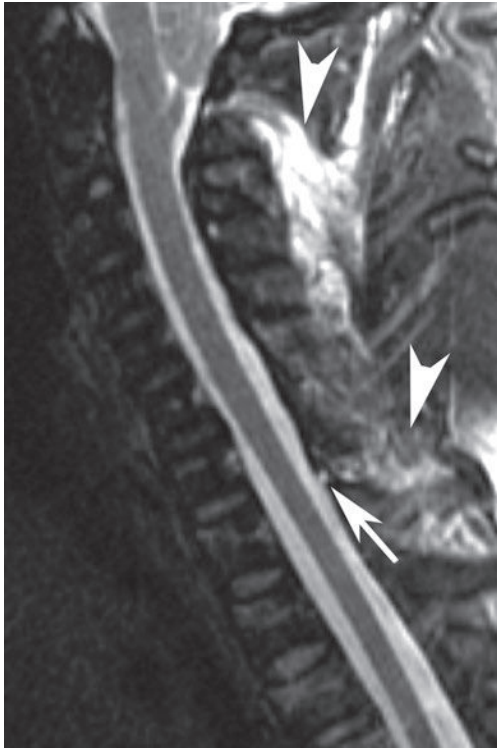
A sagittal STIR image shows edema in the supraspinous ligament region (*arrowheads*) and interspinous region at C6-C7 and C7-T1, with a small, focal region of increased T2-weighted signal in the ligamentum flavum at the C7-T1 level (*arrow*) compatible with a partial tear.[†]
